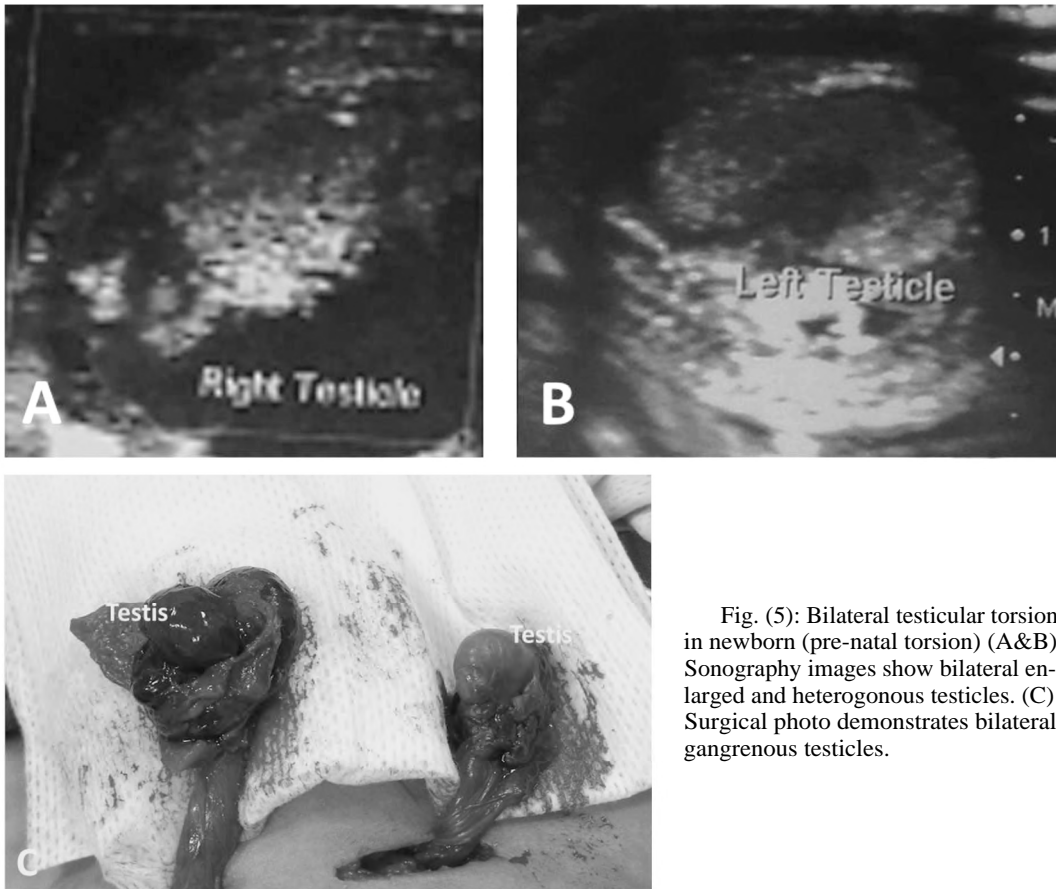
Bilateral testicular torsion in newborn (pre-natal torsion) (A&B) Sonography images show bilateral enlarged and heterogenous testicles. (C) Surgical photo demonstrates bilateral gangrenous testicles.
